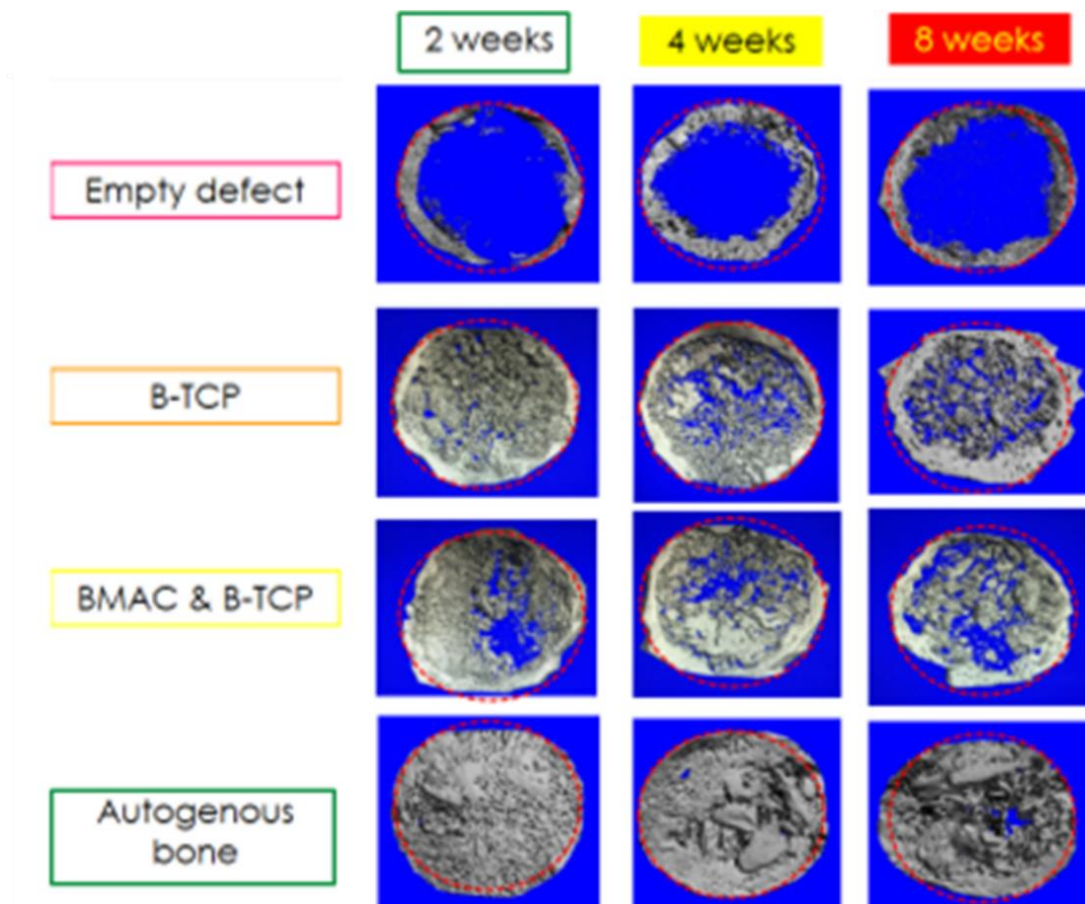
The 3-D reconstruction of the defects using μ -CT over the observation periods in axial cut.
